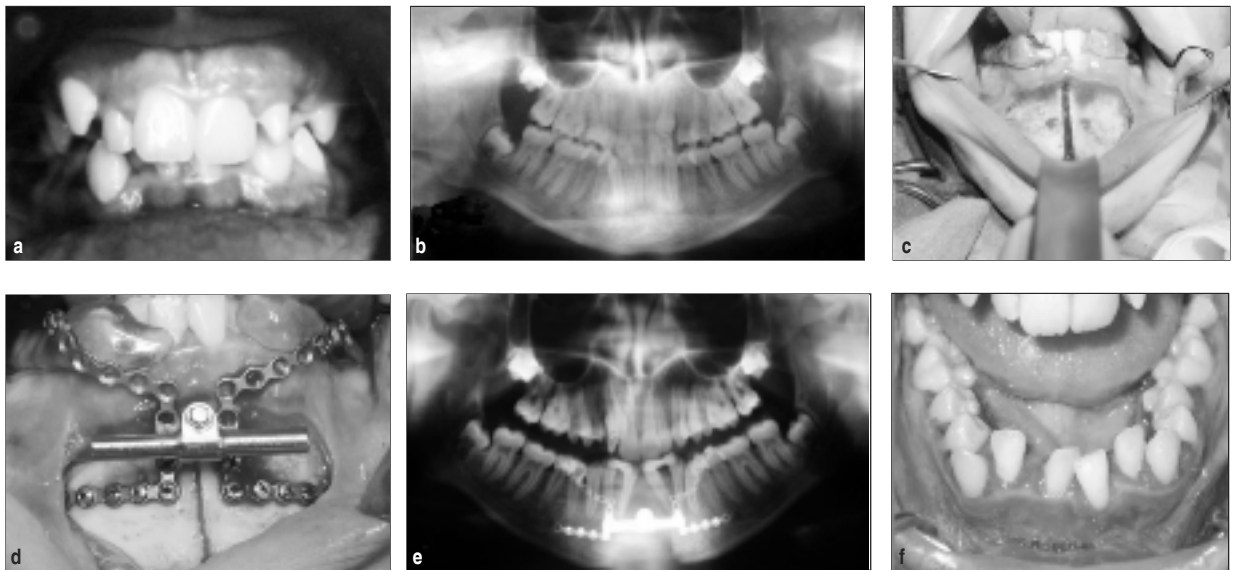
a) Preoperative clinical appearance of the patient, b) Preoperative panoramic radiography of the patient, c) Intraoperative view of the osteotomy line, d) Intraoperative placement of the distractor in case 1, e) Postoperative radiographic appearance of case 1 after a consolidation period of three months, f) Postoperative intraoral clinical view of the distraction area.
